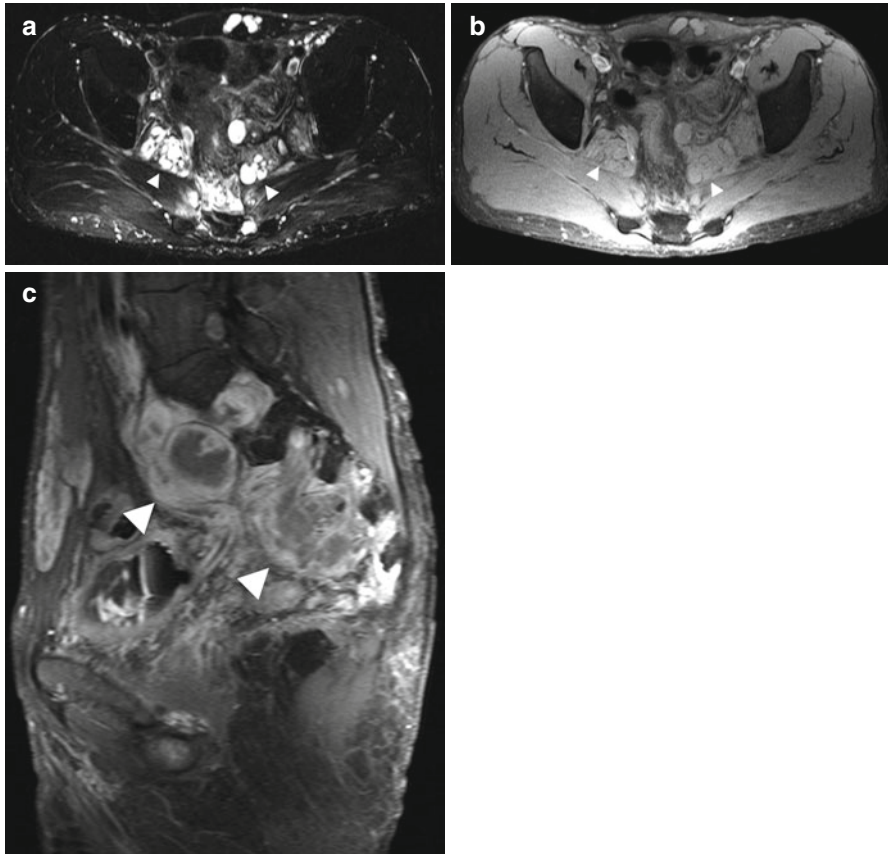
Incidental screening finding and diagnostic workup. Twenty-five-year-old male subject with multiple spherical masses of high signal intensity (*arrowheads*) along the course of the lumbosacral plexus and within the abdominal muscles on axial T2w TSE image with fat suppression (a). Diagnostic workup with an additional MRI examination including IV administration of contrast medium reveals multiple neurofibromas of the lumbosacral plexus (*arrowheads*), which are isointense to muscle on fat-suppressed axial T1w TSE image (b) and exhibit peripheral enhancement on corresponding sagittal image acquired after IV contrast medium administration (c). Neurofibromas typically distend the neuroforamina
